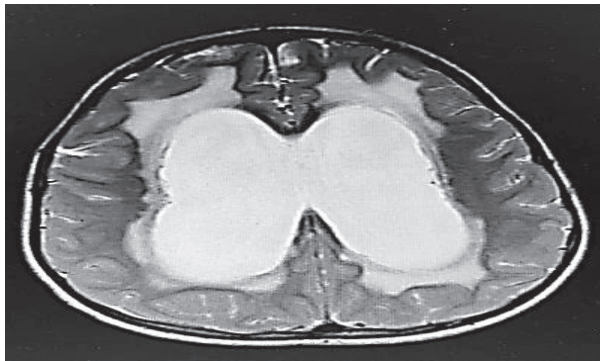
Axial MRI T2-Weighted Image Showing the Enlarged Lateral Ventricles
